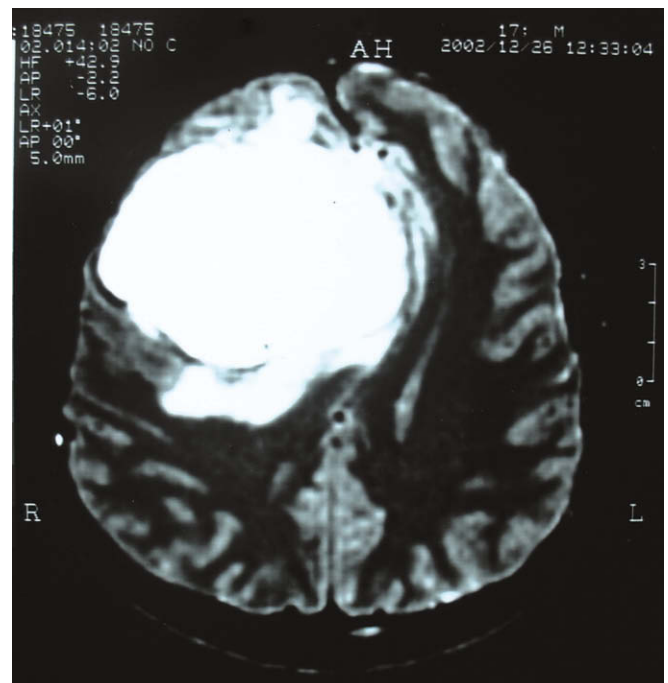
T₂-weighted axial MRI showing a huge right frontal mass and midline shift.
